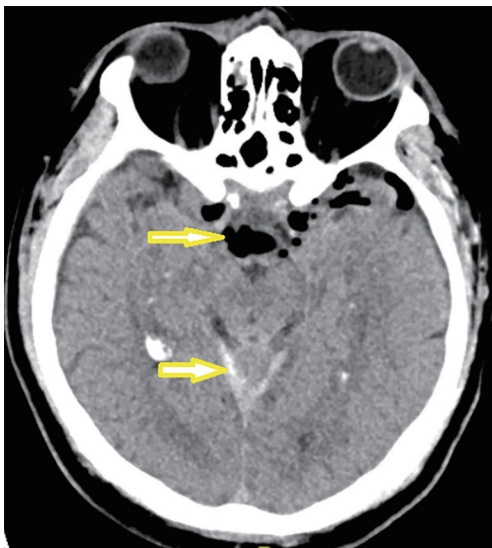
Post-operative axial brain CT scan showing pneumocephalus on basal cisterns (anterior arrow), and acute subdural hematoma on the tentorium leaflet (posterior arrow).
